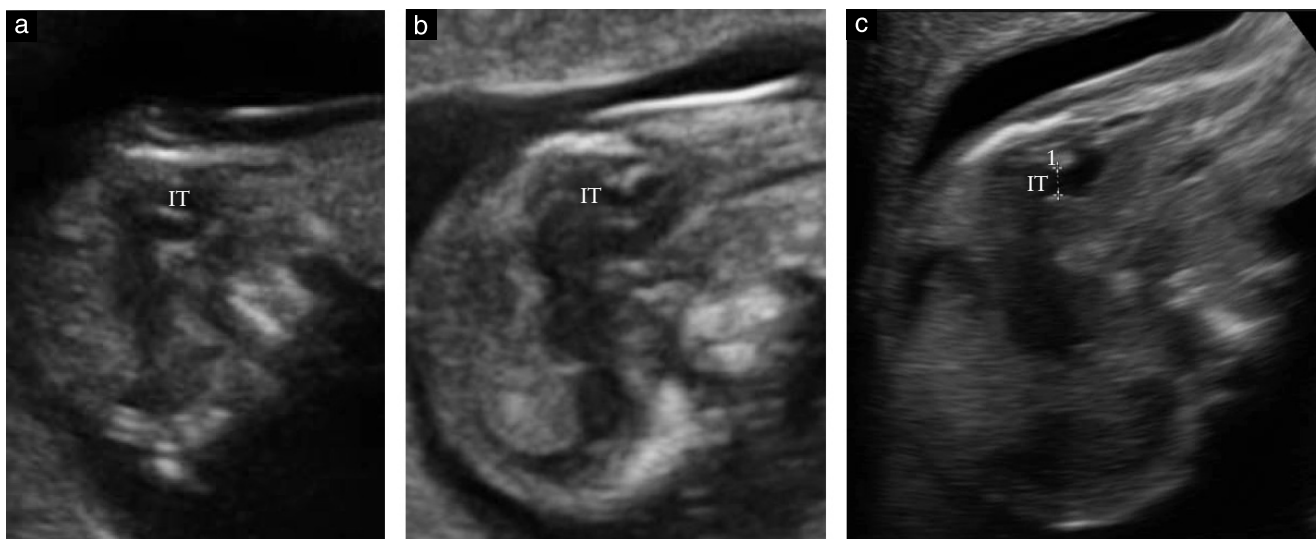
Visualization of the intracranial translucency (IT) in three fetuses in a prone position at 12 weeks' gestation (crown–rump lengths, 62–64 mm). There is shadowing of the brain by the occipital bone. Images (a) and (b) were obtained by transabdominal sonography and image (c) was obtained transvaginally.
